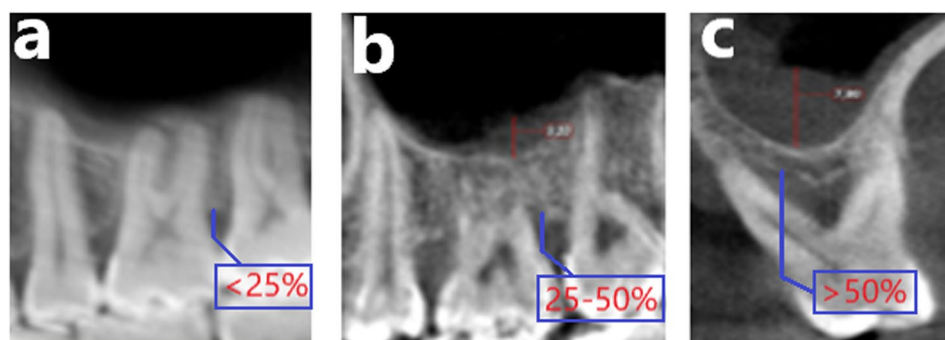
CBCT images showing the level of periodontal bone loss. a Class I (normal to mild, <25% bone loss) b Class II (moderate, 25–50% bone loss) c Class III (severe, >50% bone loss) Note: The blue line indicates the level of periodontal bone loss
